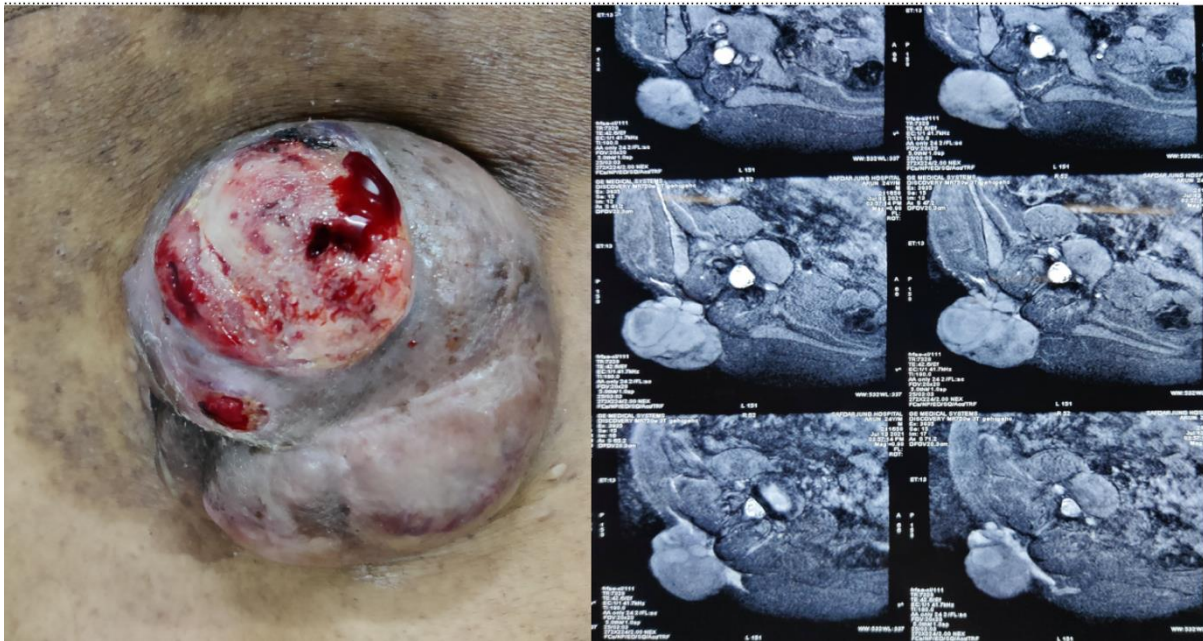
soft tissue sarcoma of lower back with active bleeding (left), MR imaging of the same (right)
